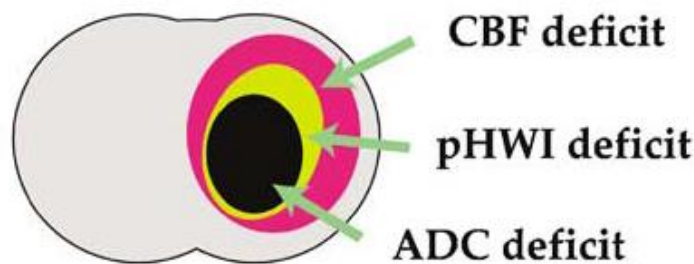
Example of ischemic cerebral tissue region that shows the areas with ADC, CBF and pHWI deficit detected using DWI, PWI and pHWI MRI, respectively. Taken from (Sun et al., 2007).
